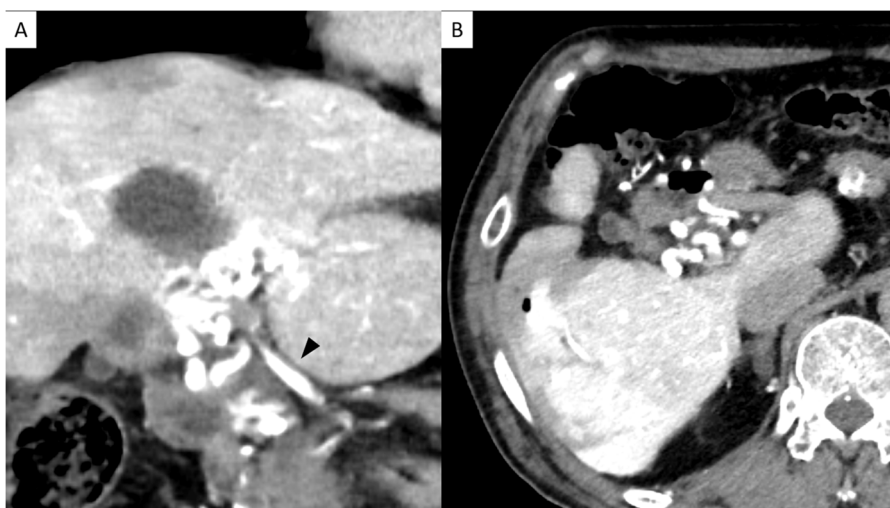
A) Axial CT angiography images of the abdomen revealed portal vein stricture (arrow) and increased presence of collateral veins around the liver hilum. B) Coronal CT angiography image of the abdomen revealed similar findings.
